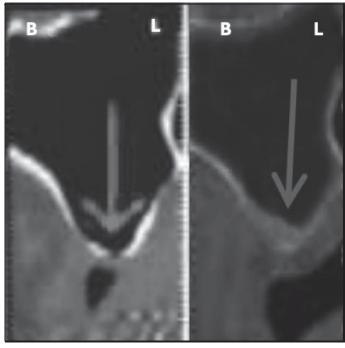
3D X-ray examination in coronal section before and after closure of oroantral communication.
